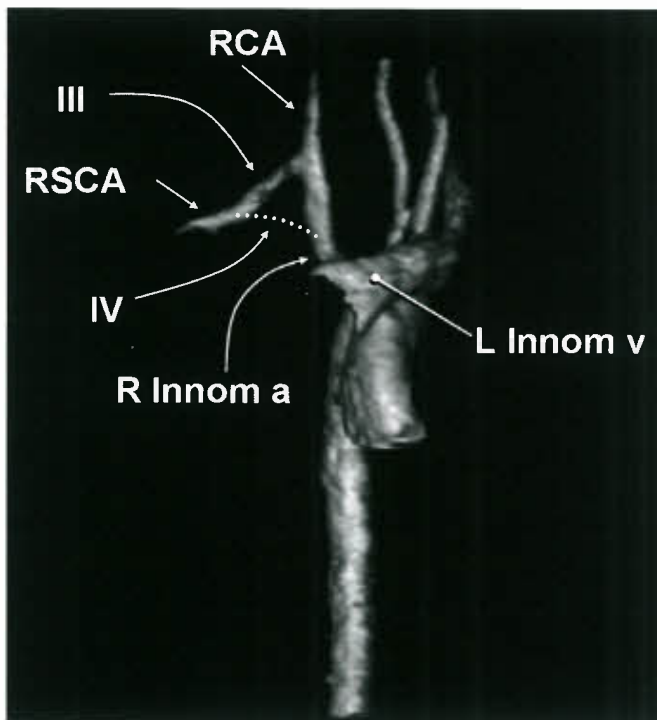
Cervical origin of the right subclavian artery. Slightly right anterior oblique view of 3-D shaded surface display from MRI. Note the high (i.e., cervical) origin of the RSCA from the right innominate artery (R Innom a) and the downward course into the thorax. Compare with Figure 22.2A. Dotted line shows expected location of absent embryonic fourth arch (IV). Note superior location of embryonic third arch (III) component of RSCA. L innom v, left innominate vein.
